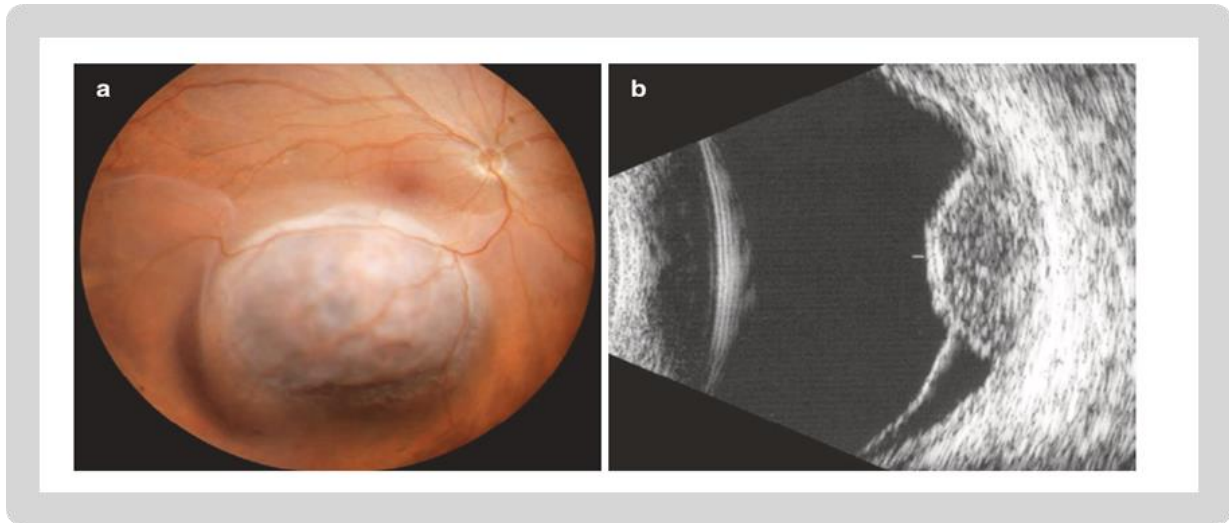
Dome-shaped choroidal melanoma in which there is a secondary serous retinal detachment. (a) Fundoscopy image. (b) Ultrasonography (image sourced from Singh, 2019) [127].
